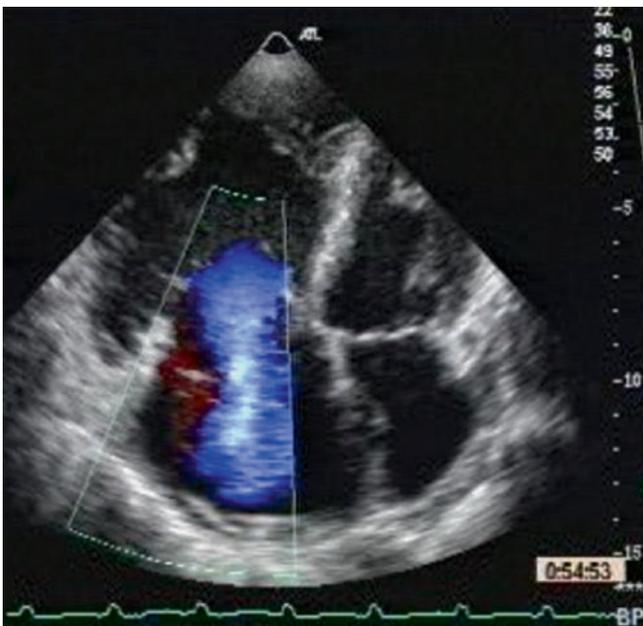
Apical four-chamber projection with colour Doppler demonstrating the presence of almost free tricuspid regurgitation secondary to the marked dilatation of the tricuspid annulus. Notice the low velocity flow as seen by the deep blue colour of the velocity jet
